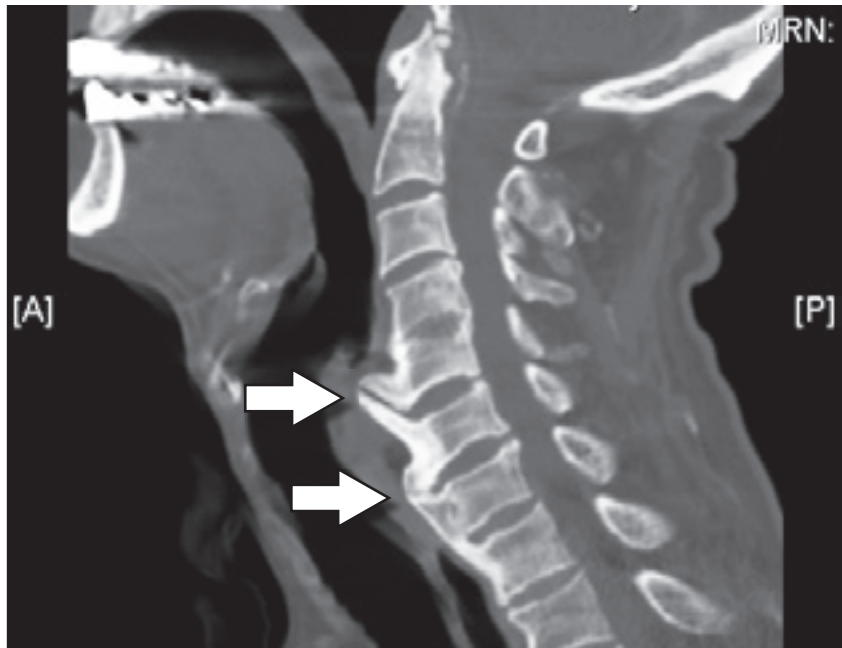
Sagittal CT image of the cervical spine showing large anterior osteophytes extending from C5 to C7.
